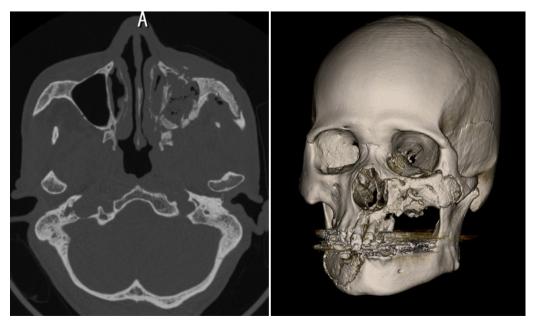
CT and 3D reconstructed CT photography. CT shows sequestration over nearly the entire extent of the left half of the maxilla, reaching the infraorbital margin or zygomatic bone.
